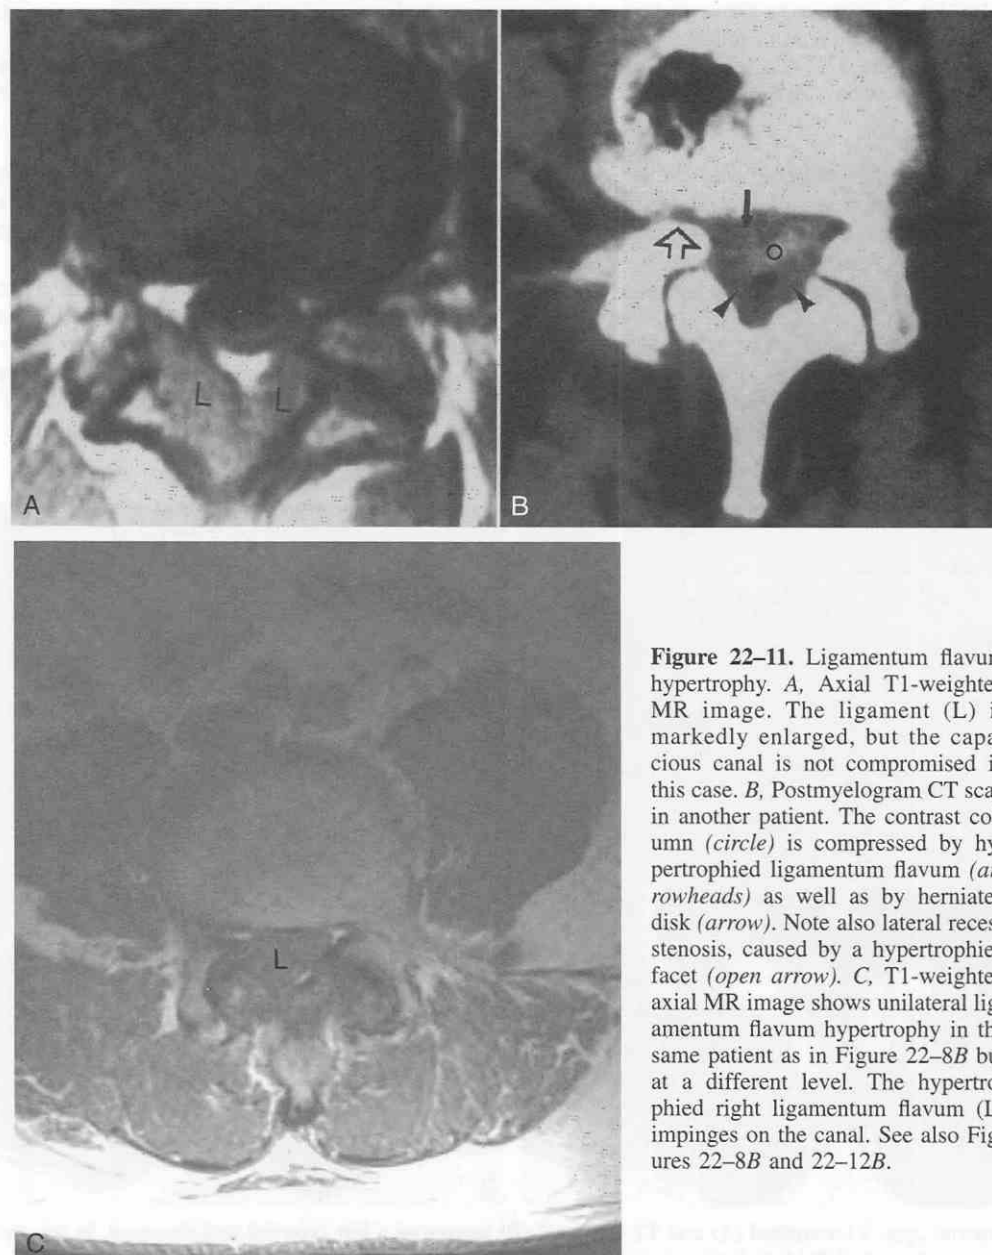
Ligamentum flavum hypertrophy. A, Axial T1-weighted MR image. The ligament (L) is markedly enlarged, but the capacious canal is not compromised in this case. B, Postmyelogram CT scan in another patient. The contrast column (*circle*) is compressed by hypertrophied ligamentum flavum (*arrowheads*) as well as by herniated disk (*arrow*). Note also lateral recess stenosis, caused by a hypertrophied facet (*open arrow*). C, T1-weighted axial MR image shows unilateral ligamentum flavum hypertrophy in the same patient as in Figure 22-8B but at a different level. The hypertrophied right ligamentum flavum (L) impinges on the canal. See also Figures 22-8B and 22-12B.
